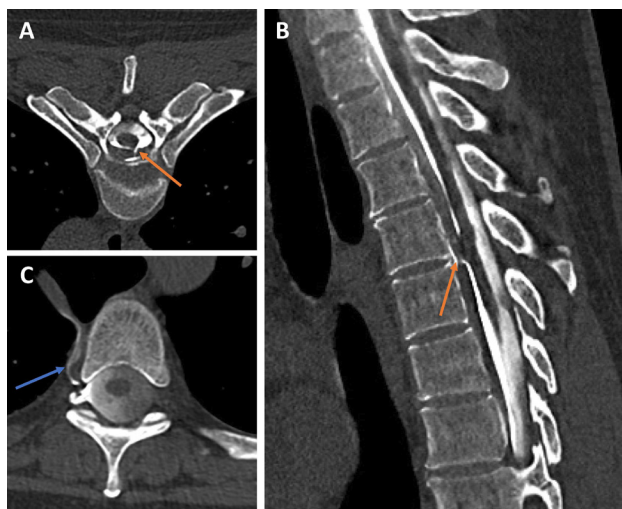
CSF leak and CSF venous fistula identified using CT myelography. Axial (A) and sagittal (B) sections from a hyperfast dynamic CT myelogram show an upper thoracic ventral leak. There is a jet of contrast extravasation at the intervertebral space (orange arrows). In a different patient (C), a lateral decubitus dynamic CT myelogram depicts a right-sided CSF venous fistula (blue arrow). Contrast extends from a root sleeve diverticulum into a right paraspinal segmental vein, and subsequently into the azygos vein (which in this case, lies in an azygos fissure). CSF, cerebrospinal fluid.
